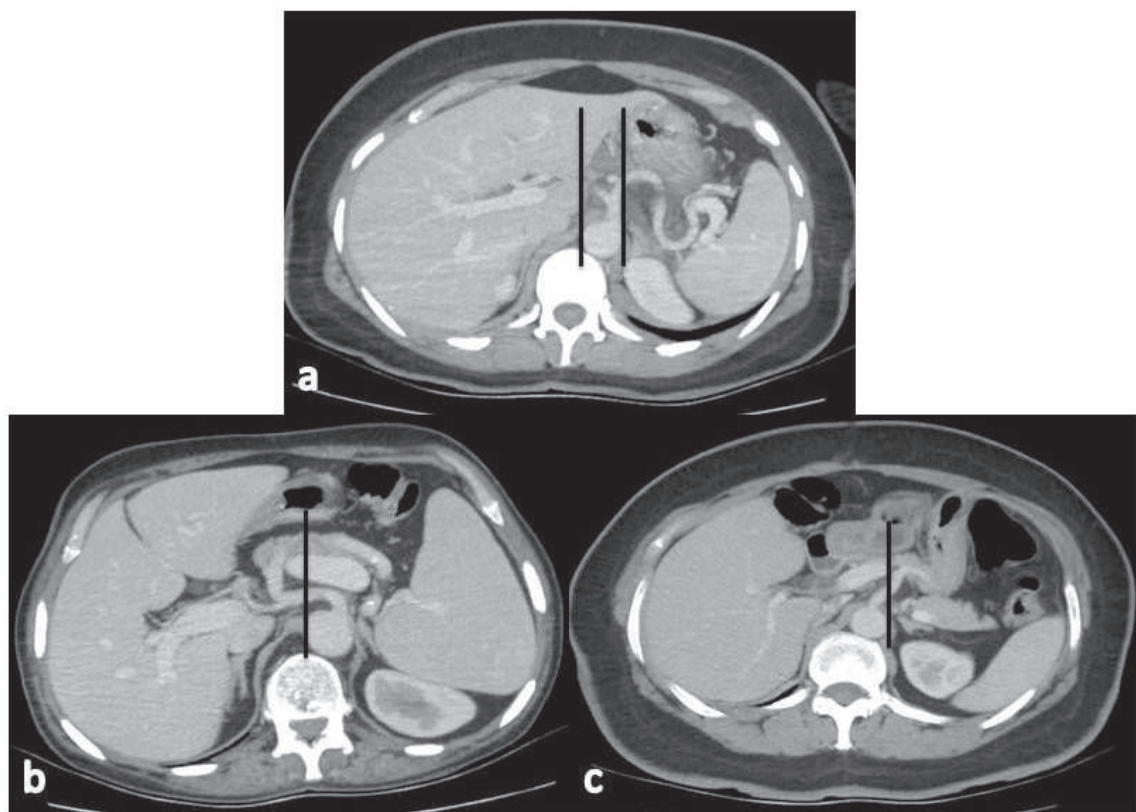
Axial contrast-enhanced abdominal CT image a. Direction of the celiac trunk is straight forward within the imaginary lines at the margins of abdominal aorta. b. Rightward direction of the celiac trunk. c. Leftward direction of the celiac trunk.
